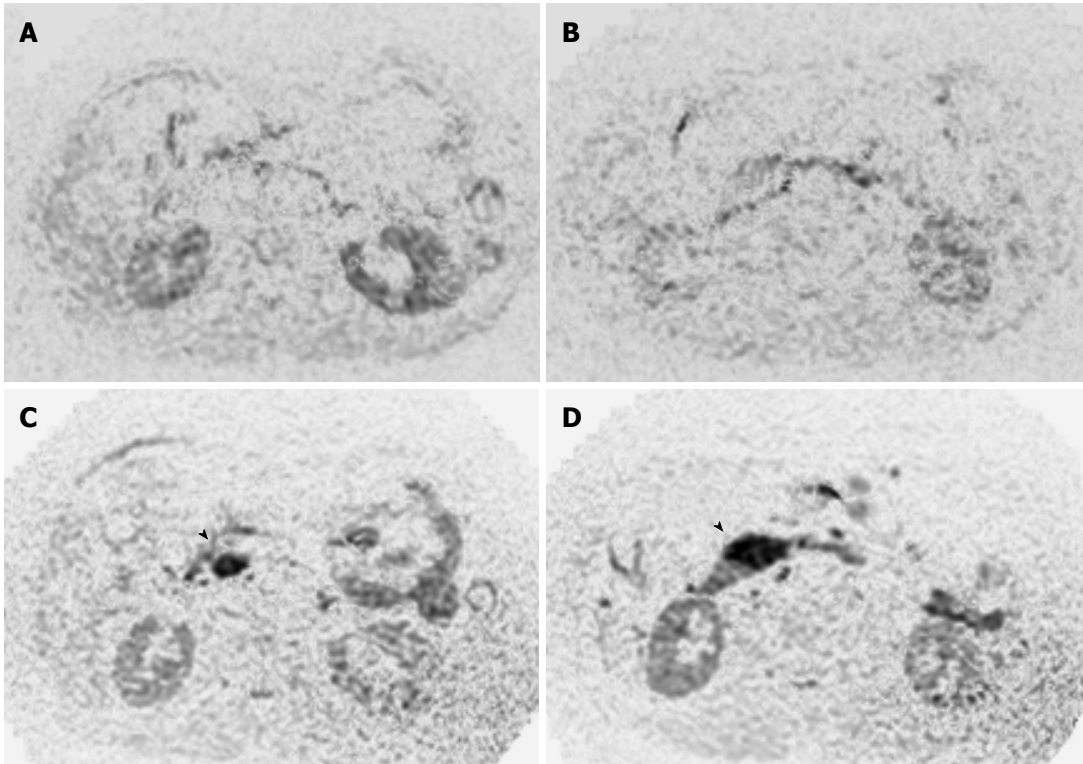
Diffusion-weighted magnetic resonance imaging. A, B: In 2008, diffusion-weighted imaging showed no signal in the pancreas; C, D: In 2011, diffusion-weighted imaging showed high-intensity signals (arrow-head) corresponding to both cystic lesions in the pancreas.
